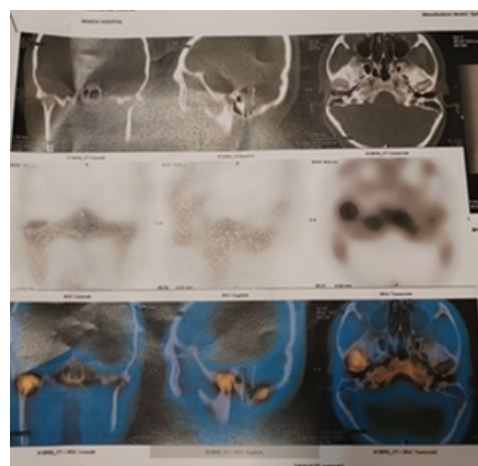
SPECT view of condylar activity.
